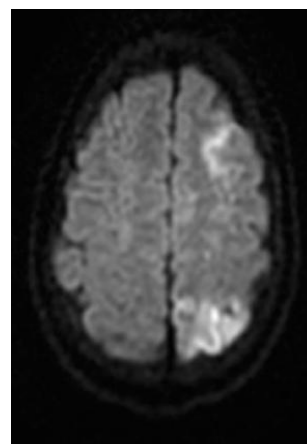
Initial Diffusion-weighted imaging (DWI) MRI of the brain displaying acute ischemia in the left frontal and parietal lobes with no mass effect.
